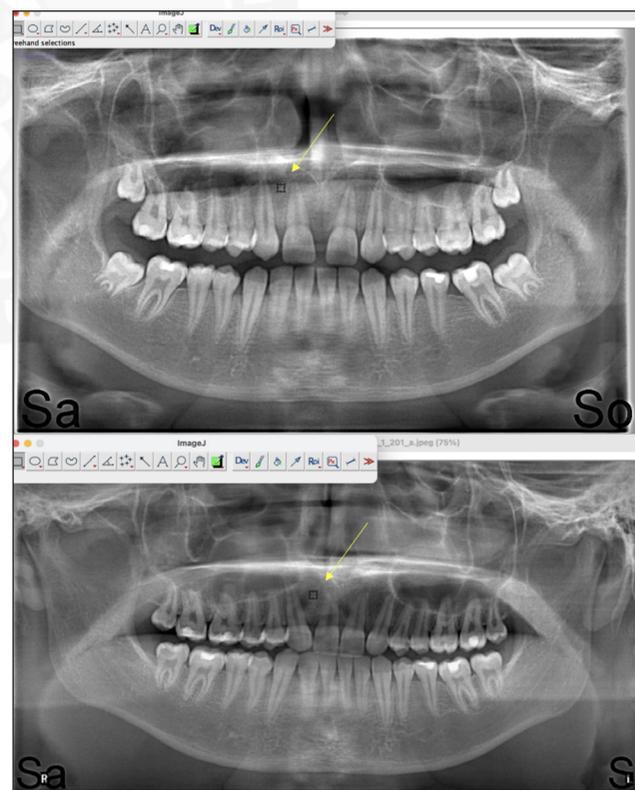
Selection of a 20x20 pixel area of interest on a panoramic radiograph before (panoramic radiograph above) and after (panoramic radiograph below) space-opening treatment. The yellow arrow indicates the selected area of interest.
